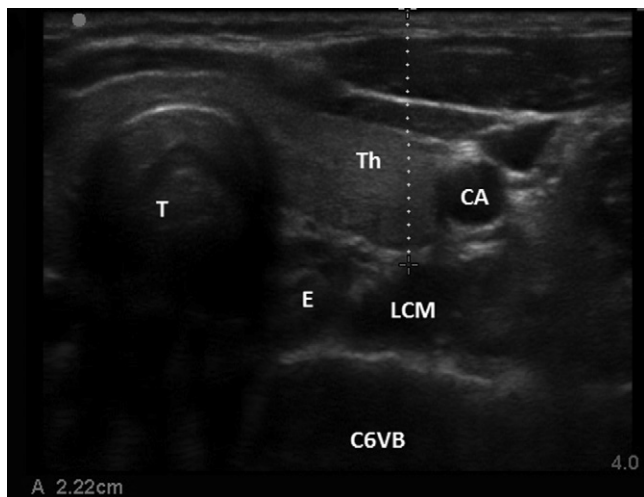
Linear transducer positioned at cricoid cartilage level (*right*); sonogram of anterior neck (*left*). T, trachea; E, esophagus; Th, thyroid; CA, carotid artery; SCM, sternocleidomastoid muscle; LCM, longus colli muscle; C6, exiting C6 nerve root; C6 VB, C6 vertebral body; *white line*, contours of C6 vertebra.
